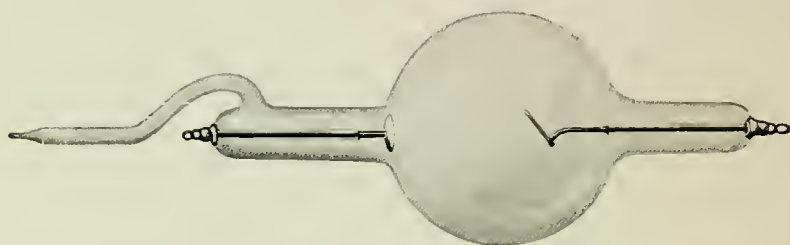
Modern X-Ray Tube.
